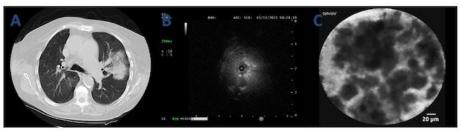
A. Axial CT image showing left upper lobe lesion B. Concentric lesion on rEBUS view C. CLE-Cellvizio image showing areas of dark "clumps" suggestive of abnormal tissue deposits.
